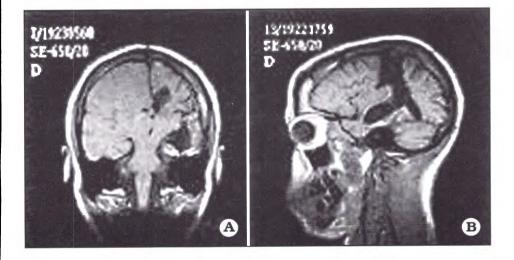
A. MRI: coronal view showing temporal lobe emptying, as well as central area resection. B. MRI: sagittal view corresponding to the same patient.
